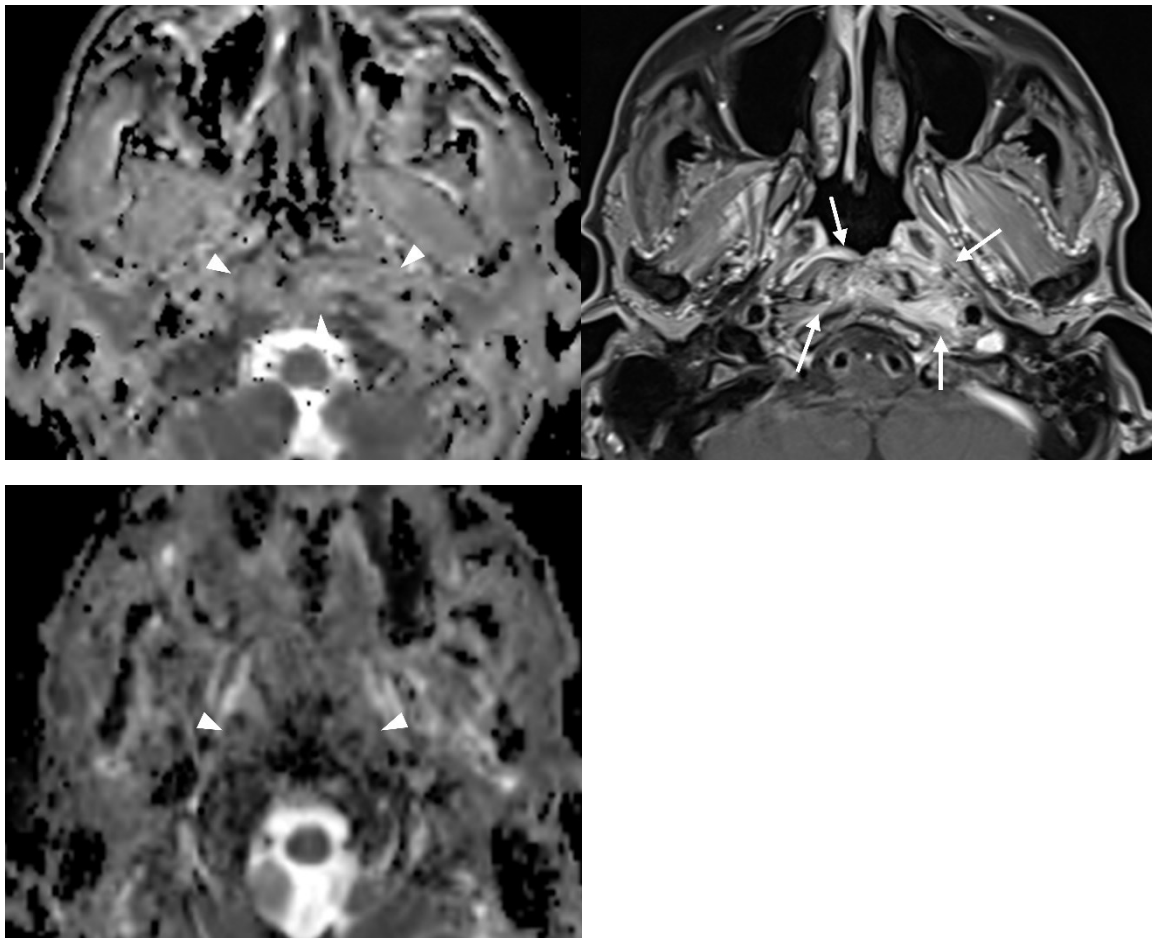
72-year-old male with skull base osteomyelitis. Post-contrast fat-suppressed T1-weighted image (A) shows ill-defined enhancement (arrows) in the nasopharynx, prevertebral space, and left parapharyngeal space (arrows). The pre-treatment apparent diffusion coefficient (ADC) value is $1.49 \times 10^{-3} \text{ mm}^2/\text{s}$ (B, arrowheads) and the post-treatment ADC value is $0.94 \times 10^{-3} \text{ mm}^2/\text{s}$ (C, arrowheads), and such a reduction of ADC values indicates a good response to treatment.
